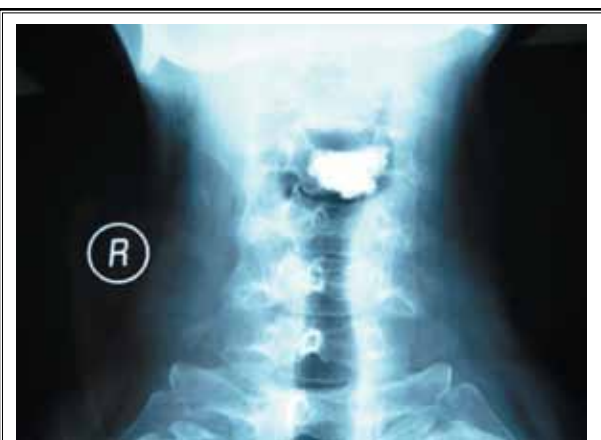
Postoperative AP radiograph of a 52-year-old male with symptomatic C4 VH showed cement filling within the vertebral body.
